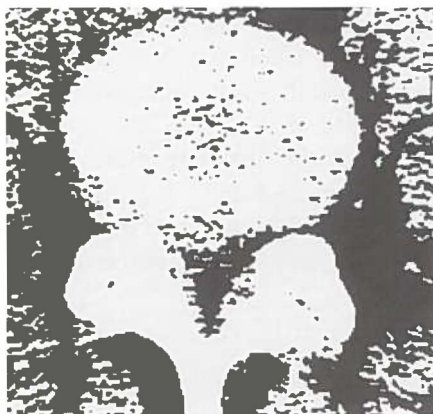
Case 3. Same CT scan as in Fig. 3.17; blink method, with the same window width and window level adjustments as in Fig.3.16, demonstrating unchanged disc protrusion and increased annular bulging at three months.
